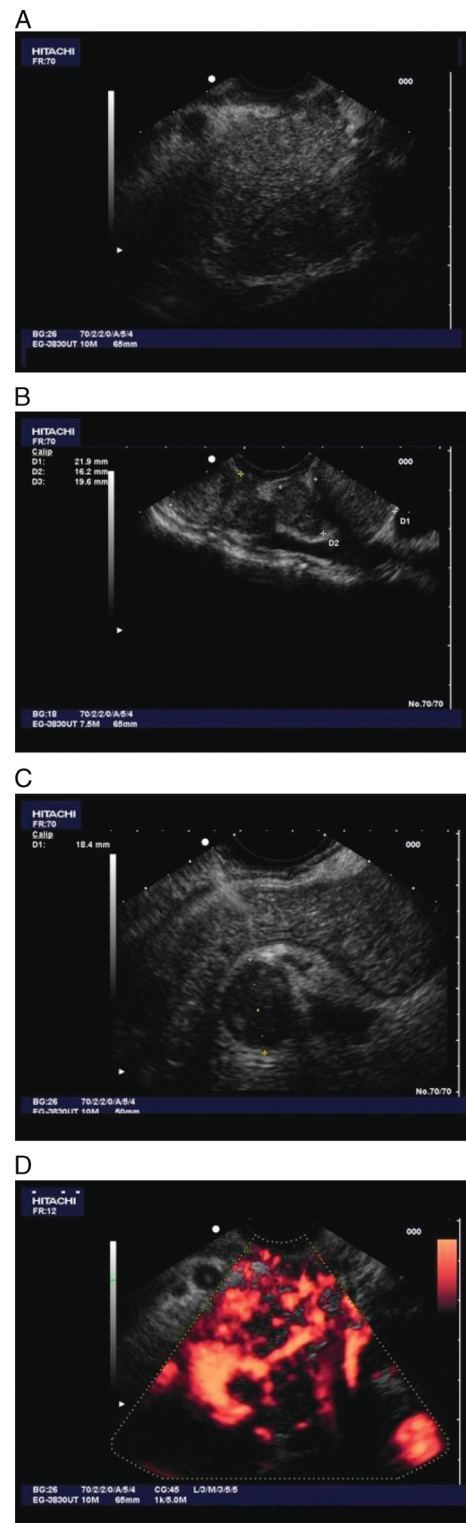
Acinar cell carcinoma. A 73-y-old man. Painless jaundice. Enlarged pancreatic head on US and CT, pancreatic duct slightly dilated (4 mm), with abrupture at the pancreatic head. EUS shows an enlarged hypoechoic pancreatic head (A) and multiple rounded and enlarged lymph nodes in the mediastinum and abdomen (B: paraesophageal and C: paraduodenal lymph nodes). EUS with contrast-enhanced power Doppler with 1 mL SonoVue intravenously administered shows hypervascularity of the pancreatic head. The diagnosis of metastatic ACC was confirmed by EUS-FNA of both the pancreatic head and mediastinal lymph nodes.
